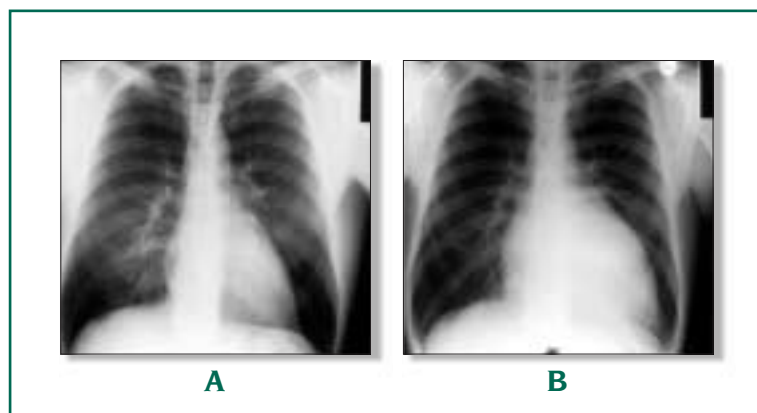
X-ray images of patients with: (A) tachycardia-induced cardiomyopathy: sinus rhythm; (B) persistent atrial fibrillation with rapid ventricular rates for 3 months.
